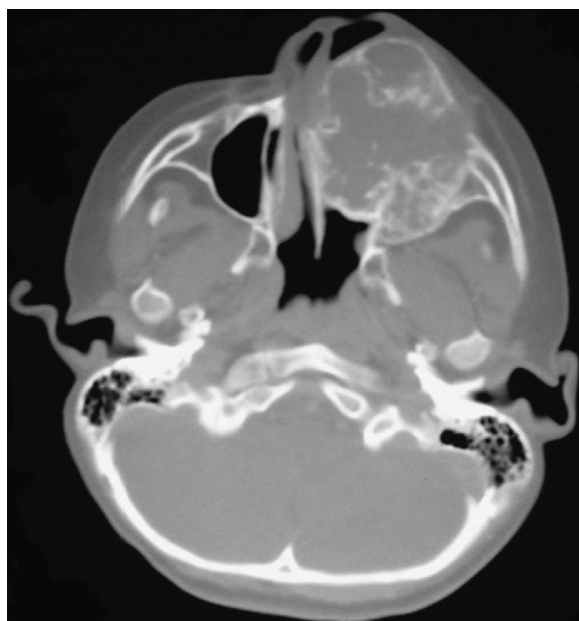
Non-contrasted axial CT scan demonstrating a large maxillary sinus mass with facial distortion.
